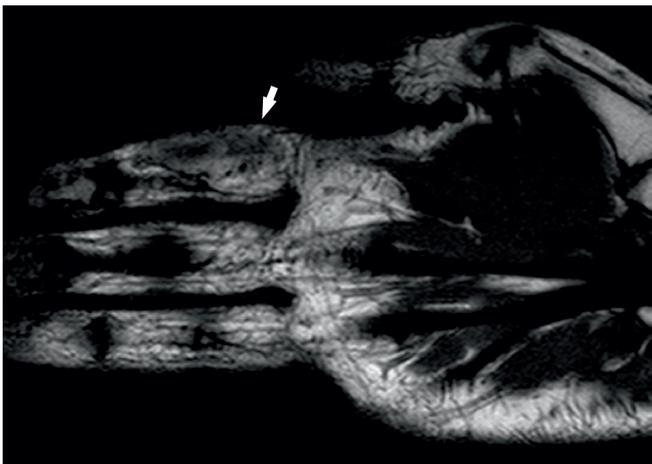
Coronal plane MRI, any pathological signs was not shown bone, tendons, and muscular structure (white arrow).
